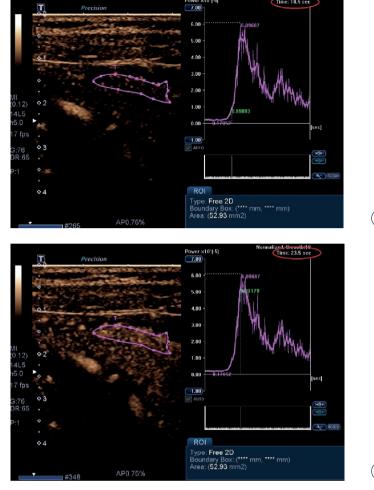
Contrast-enhanced ultrasound: the region of interest (ROI) is determined (A) when the contrast medium first appears in the affected bowel wall corresponding to starting point at time-intensity curve, (B) when the maximum enhancement was seen corresponding to peak at time-intensity curve. The calculated time-to-peak is 5 seconds (18.5 sec to 23.5).
